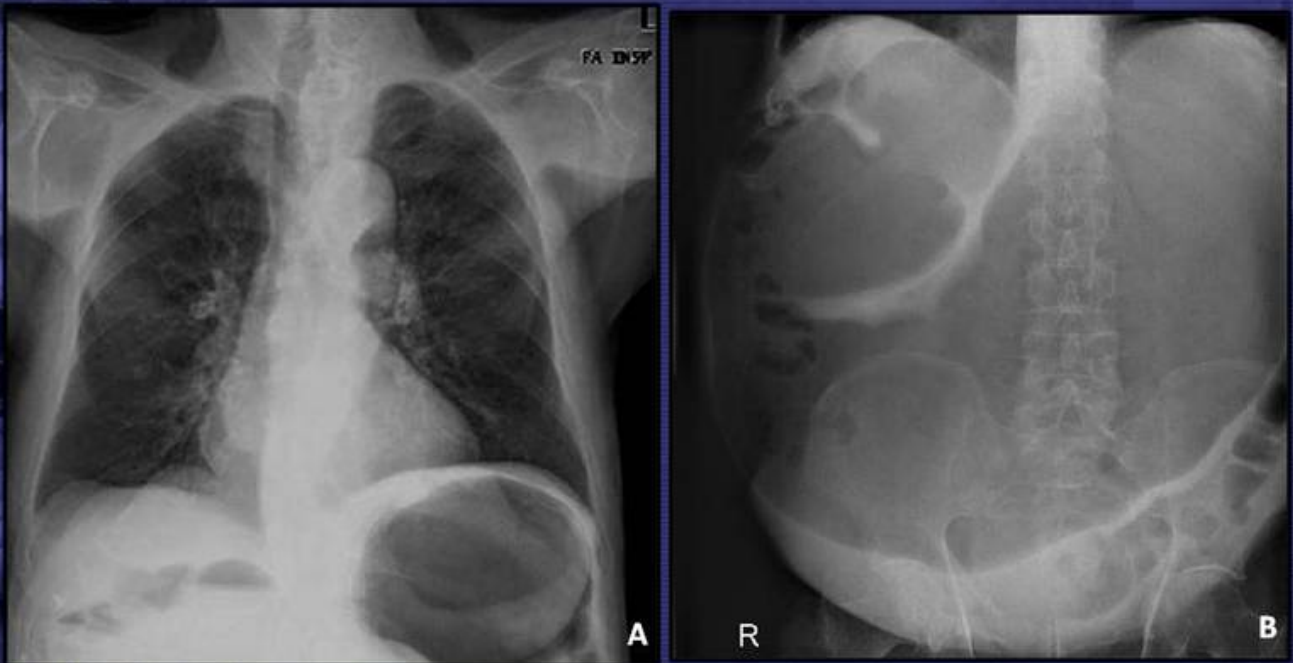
Pyloric obstruction. (A) Frontal upright chest radiograph of this 80-year-old patient shows a markedly distended gastric air bubble. (B) The supine abdominal film reveals an intensely dilated air-filled stomach due to gastric outlet obstruction.
